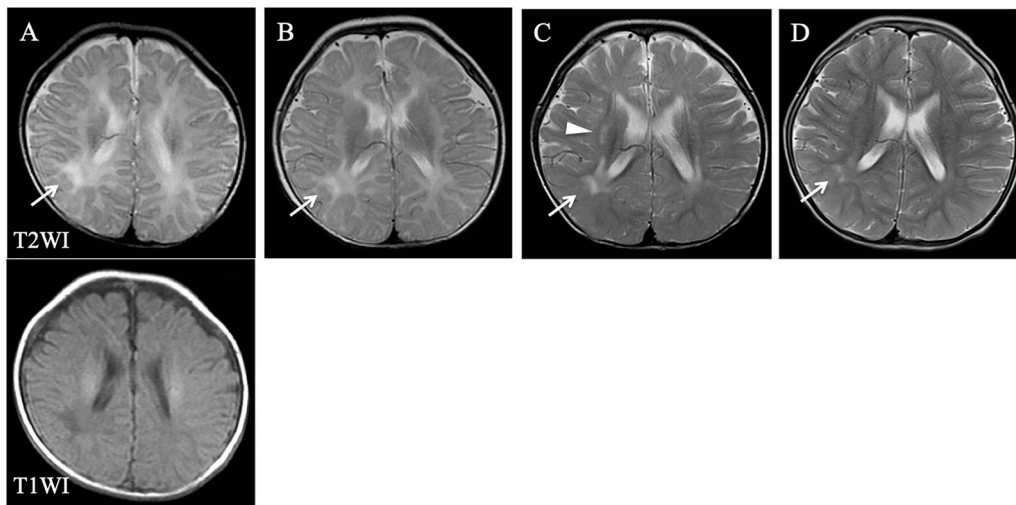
Magnetic resonance images at 2 months (A), 5 months (B), 13 months (C), and 4 years of age (D). Increased signal intensity is observed on T2WI in the white matter, especially around the trigones (arrow) and around the body of the lateral ventricle (arrowhead). This finding was most prominent at 13 months, and was not noticeable at 4 years. T1WI, T1-weighted image; T2WI, T2-weighted image.
